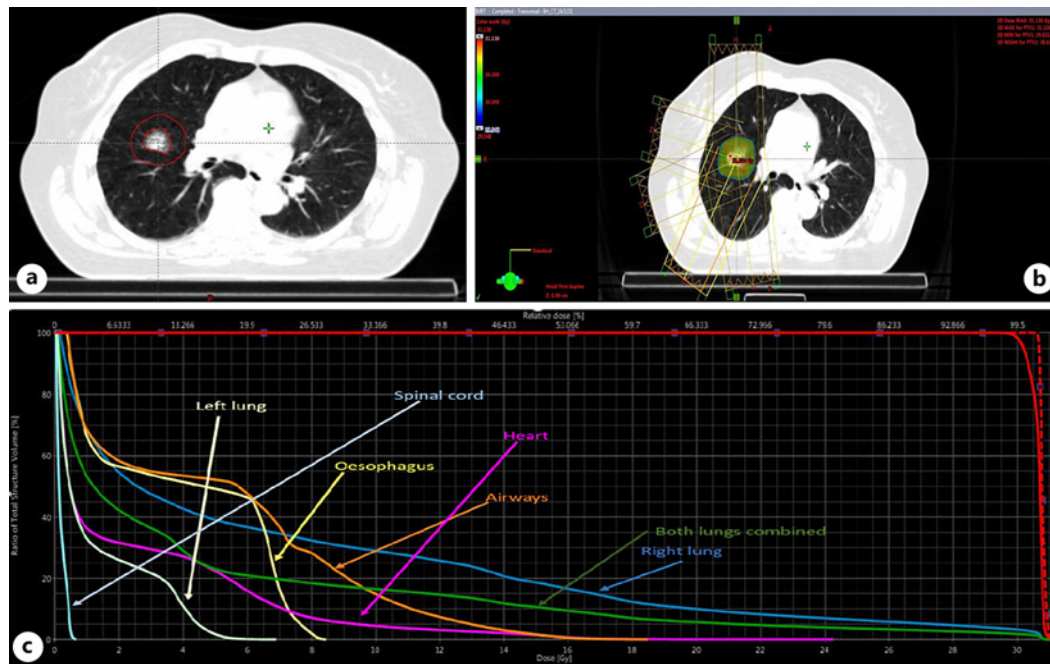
a Planning CT showing tumour GTV and PTV. b Field setup showing dose coverage. c A dose-volume histogram of the treatment. This graph quantifies the amount of radiation received by each organ and the target (tumour). The y-axis depicts the percent of the organ and the x-axis details the dose received. For example, the dose to the target is depicted by the red line. The area under the curve is large and almost 100% of the target receives the full 30 Gy. The normal organs have a limited “area under the curve” demonstrating how the technology restricts dose to critical normal structures. The mean heart dose is 2.4 Gy which is very far below acceptable limits. GTV, gross tumour volume.
